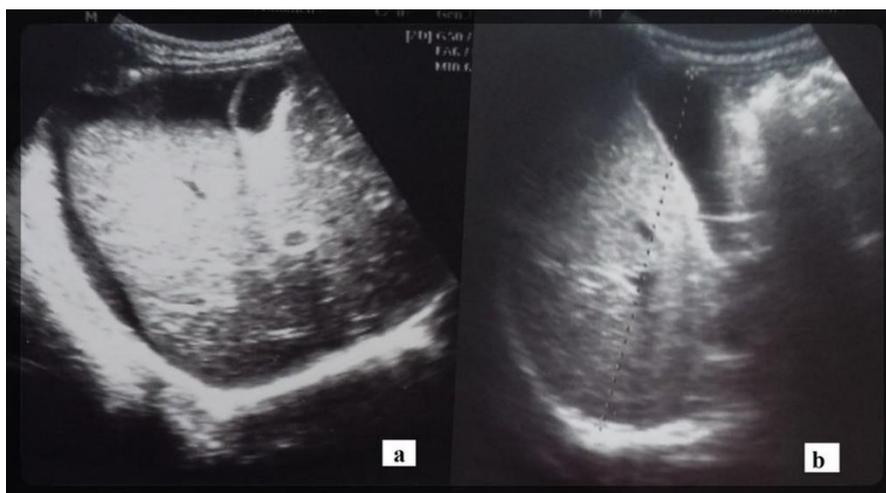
Abdominal ultrasonography: a) On day 1 of the hospital stay a large amount of perihepatic ascites is visible. b) On day 10 of the hospital stay the amount of ascites is markedly reduced.
